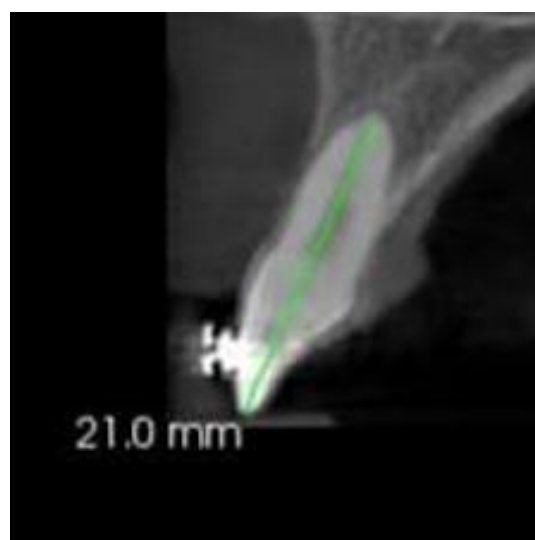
CBCT ASSESSMENT OF ROOT RESORPTION BY MEASURING CHANGES IN ROOT LENGTH OF THE MAXILLARY INCISORS.
